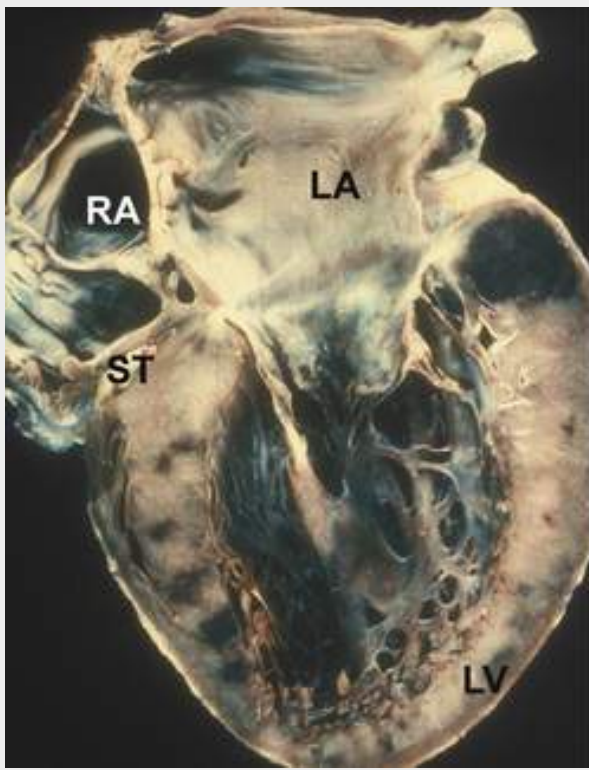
Apical four-chamber view in univentricular connection of left ventricular type with absent right connection (tricuspid atresia). Note the wedge of sulcus tissue in the floor of the right atrium. *LA*, left atrium; *LV*, left ventricle; *RA*, right atrium; *ST*, sulcus tissue.
